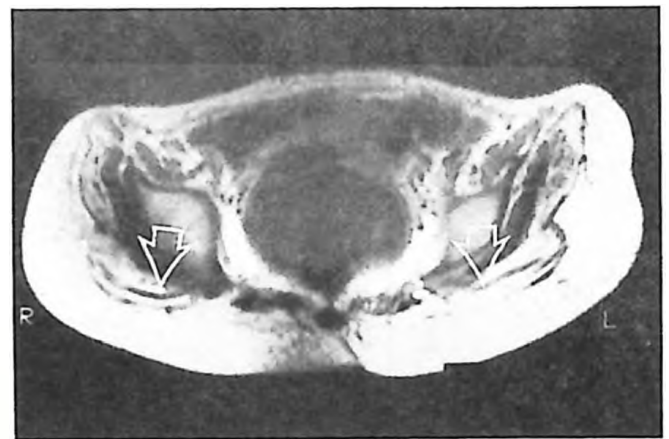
Nine-year-old patient with merosin-positive congenital muscular dystrophy (CMD) (Case 10). T1-weighted axial images of pelvic muscles demonstrate severe atrophy and intensity changes in the gluteus maximus muscles (open arrows).
